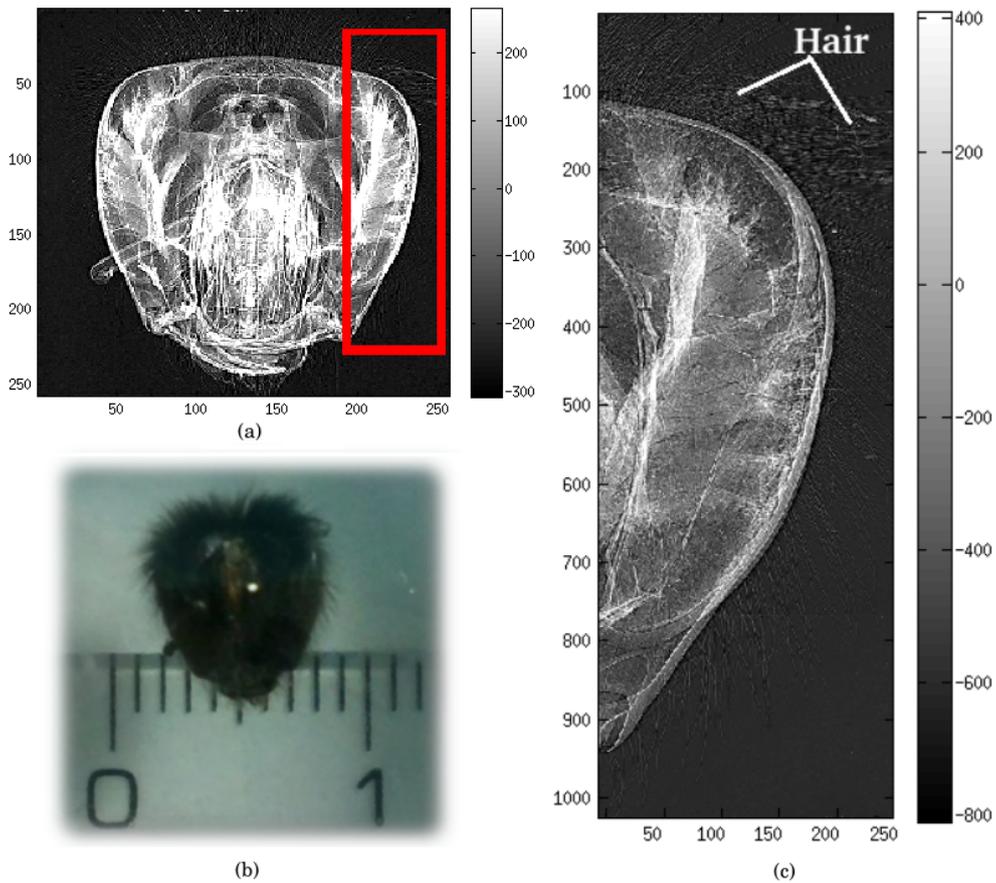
(a) Microradiograph of the head of a queen honey-bee (photo included in (b)) acquired by Medipix2 at $M = 2$. (c) Microradiograph of the of a part of the head of the same queen honey-bee (outlined by a red square in (a)) acquired with Timepix-Quad detector [13] at $M = 9$. Radiological parameters of the radiographs were 40 kV , $200\ \mu\text{A}$, 125 s , and $R1 + R2 = 67\text{ cm}$.
